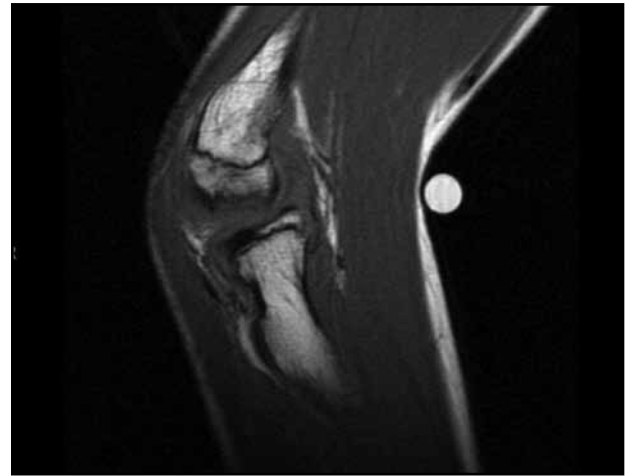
MRI scan of the same patient as seen in Fig. 2 with more extensive involvement of the humeral capitellum.
